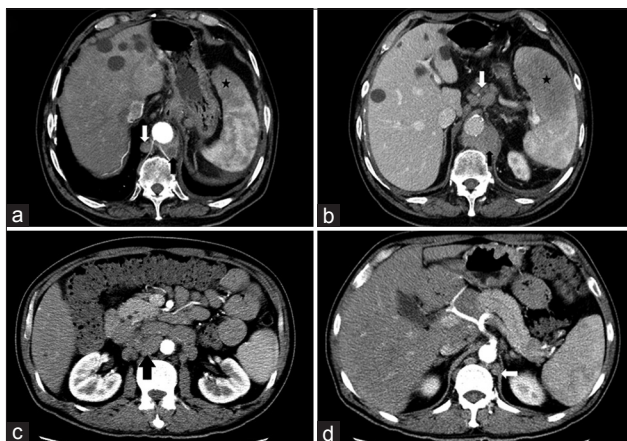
(a and b) The enhanced computed tomography images of a 55-year-old male with lymphoma showed local peripheral enhancement and relatively smooth peripheral margins of abnormal soft tissue with anterior displacement of aorta (black arrow), noted additional lymph node at para-aorta (white arrow) and spleen lesion (star); and homogeneous enhancement abnormal soft tissue with anterior displacement of aorta (black arrow), noted the enlarged lymph nodes at the lesser omentum (white arrow), splenomegaly and spleen lesion (star). (c and d) The enhanced computed tomography image of another 60-year-old male with lymphoma showed lobulated mass of soft-tissue attenuation surrounding aorta (black arrow), in addition, abdominal fat tissue was detected between aorta and lesion, noted the enlarged retrocrural nodes (white arrow) at the level of the upper pole of the kidney.
